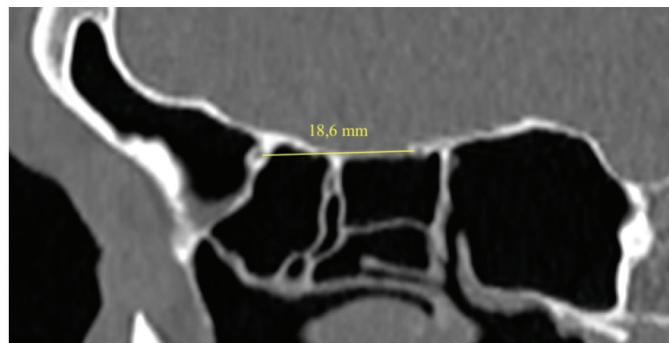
Distance between the posterior ethmoidal artery and anterior ethmoidal artery on CT scan of patient Vo Hoang V. Source: Dang Vuong Kiet, 2023.
